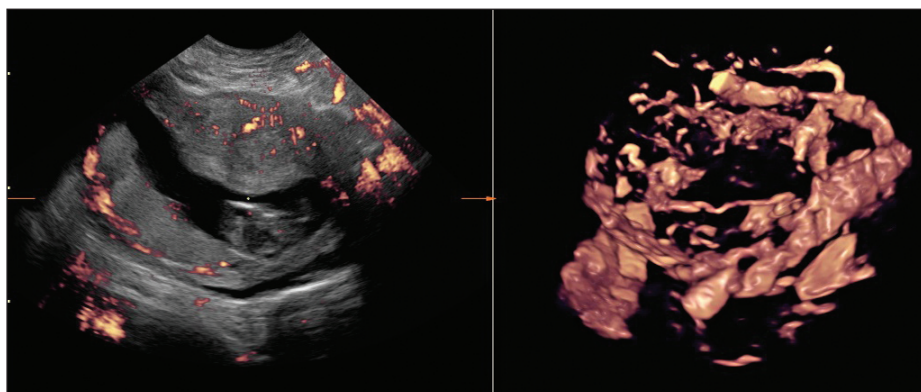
2D image on the left and the application of 3D and power Doppler on the right to demonstrate placental vascularity at 12 weeks' gestation.
